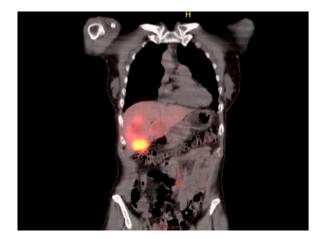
9mTc-Octreotide scintigraphy shows positive expression of somatostatin receptor in the liver and in a intestinal loop.
